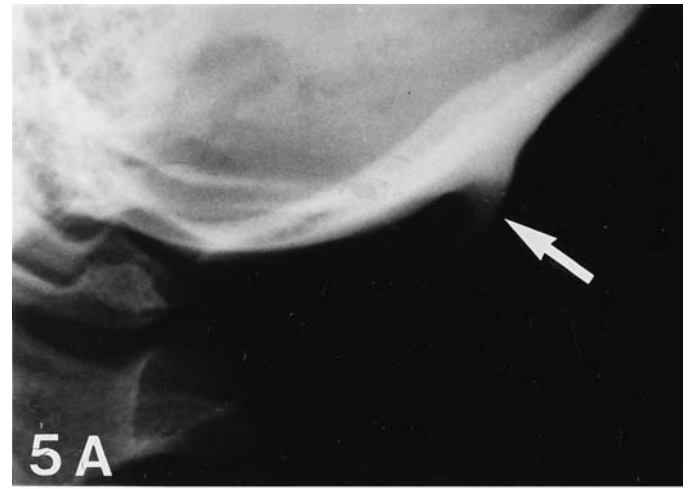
Spine like (Type 3) external occipital protuberance (arrow) in a male. A) Lateral cranium radiograph. B) Dry skull photograph.
